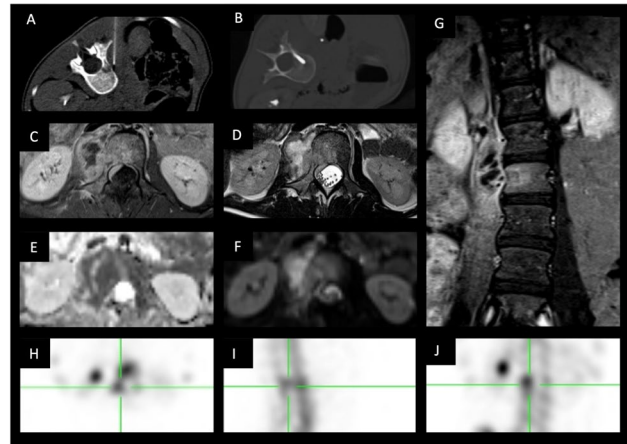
CT-guided needle aspiration (A) and bone biopsy (B) of L2 vertebral body. Lumbar MRI. (C) Axial T1-Turbo Spin Echo (TSE) fat saturation post-gadolinium and T2 TSE (D) sequences showing marked signal changes and contrast enhancement of the vertebral body and pedicle of L2, along with an anterior/right-lateral epidural collection; additionally, right psoas abscesses are present and depicted on DWI b50 (E)/ADC map (F). (G) Coronal T1-TSE fat saturation post-gadolinium demonstrating the extension of the abscesses. Bone SPECT (H), (I), (J) on axial, sagittal and coronal views revealing foci of intense hypermetabolism at the L2 vertebral body and L2 and L3 pars interarticularis.
